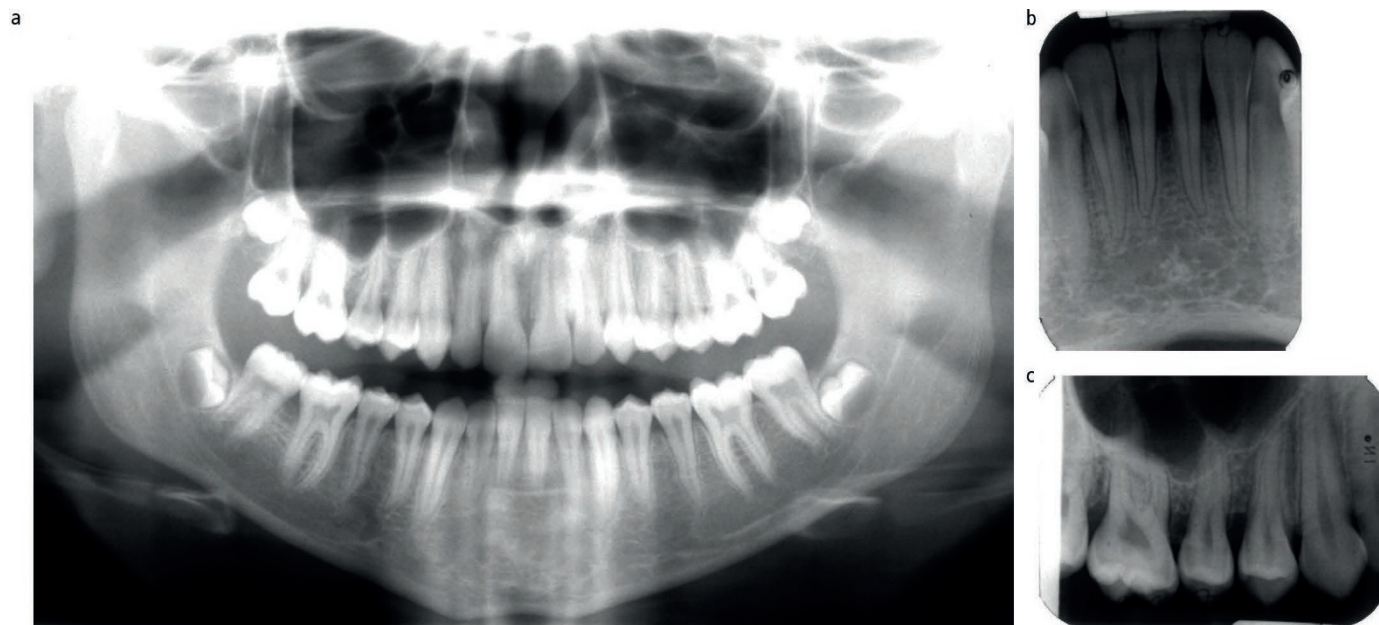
Patient 2 – a) Panoramic radiograph. b and c) selective periapical radiographs
